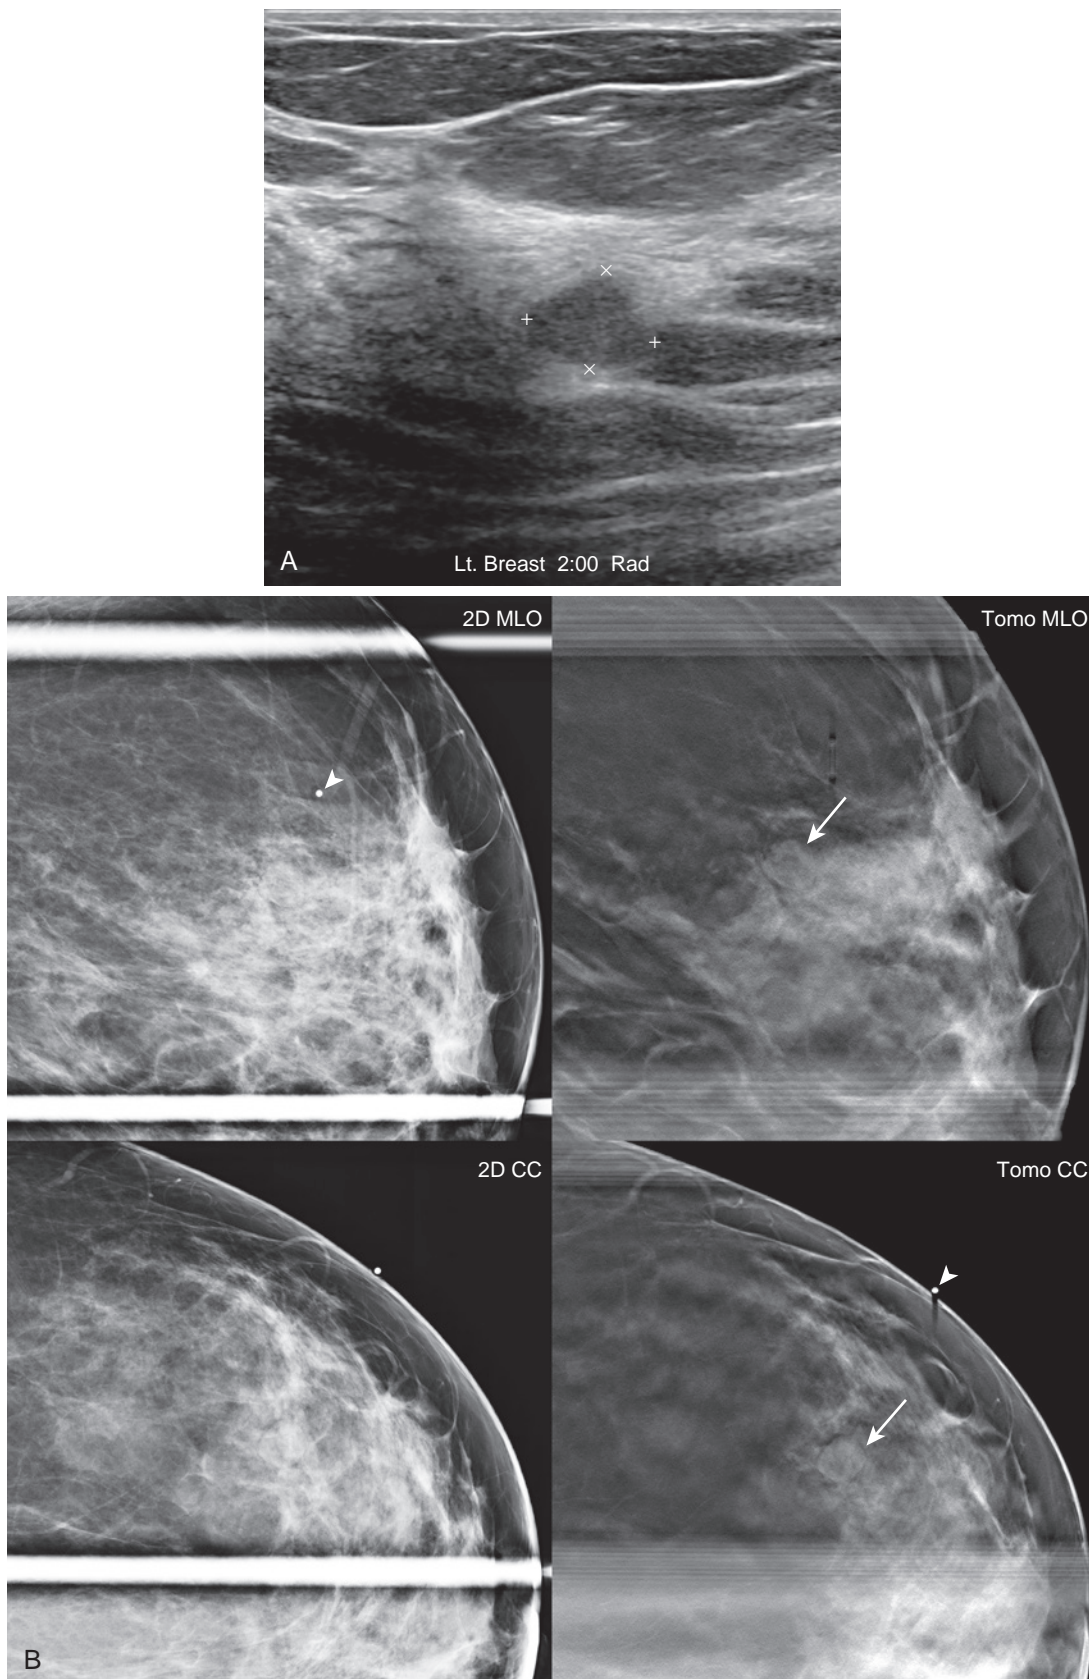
Spot compression view after BB placement can help correlate ultrasound findings. A 53-year-old woman underwent screening mammography. Prior exams were unavailable. A small mass was noted in the left breast upper outer quadrant, best seen on tomosynthesis (not shown). (A) An ultrasound was performed, which showed a 1.2-cm solid mass with circumscribed margins in the left breast 2:00 region, likely representing a fibroadenoma. (B) A BB was placed on the overlying skin (*arrowheads*), and tomo spot views were obtained showing the lesion (*arrows*), correlated with the mammographic finding. Because there were no remote comparison studies, a BI-RADS 3 final assessment was given and the mass was stable at a 6-month follow-up ultrasound.
